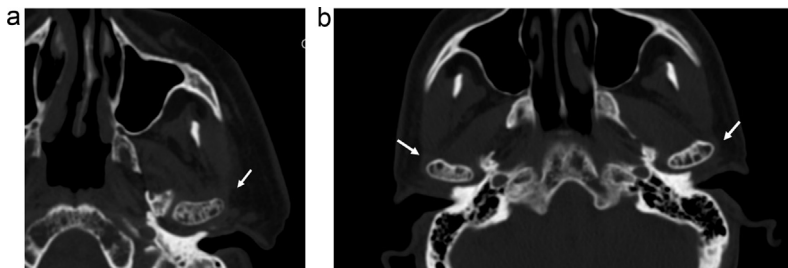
Examples of the myelomatosis pattern. (A) Axial CT scan demonstrating multiple well-circumscribed lytic bone lesions (white arrow) of the left condylar head. (B) Axial CT scan demonstrating bilateral involvement of condylar heads with multiple well-circumscribed lytic bone lesions (white arrows).
